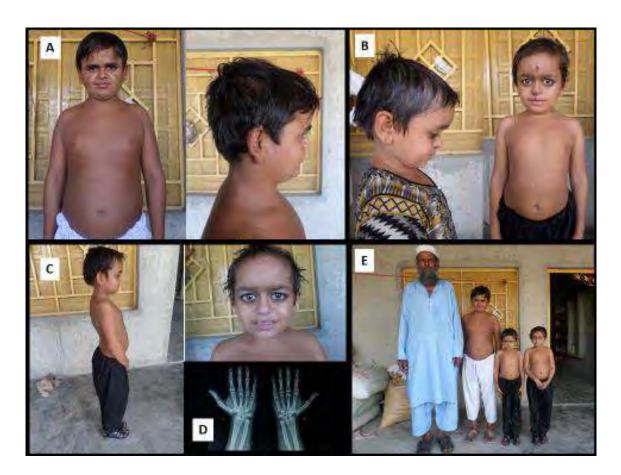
Phenotypic representation of Laron syndrome A) 401 with short stature and truncal obesity; Lateral view of face with protruding forehead, depressed nose and large ears. B) 404 truncal obesity, protruding forehead, large ears and sparse hair. C) Short stature in lateral view, blue sclera with crowded malformed teeth. D) X-ray of hands depicting the delayed bone age and late epiphyseal closure at the age of 19 of subject 401. E) A complete family picture depicting short stature with the normal person of family.
